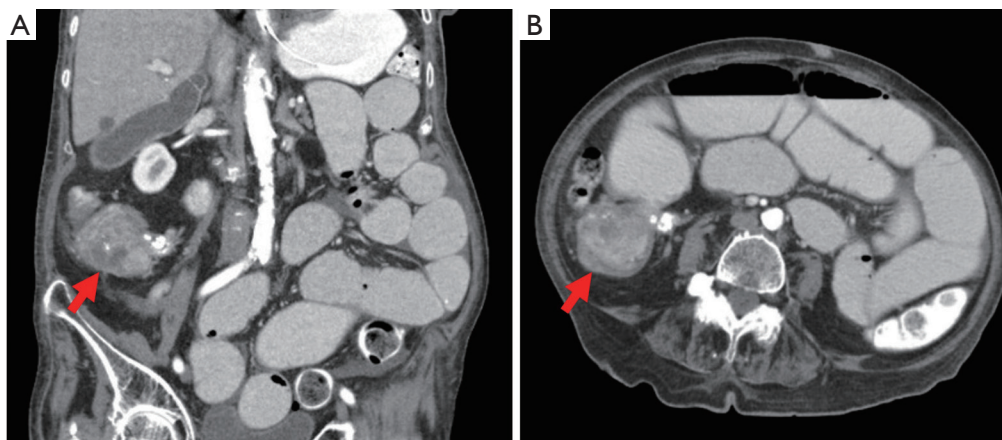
Computed tomography of the abdomen and pelvis demonstrating collision tumor of cecum and ileocecal valve: (A) coronal and (B) axial cross-sectional imaging, demonstrated with red arrows.
